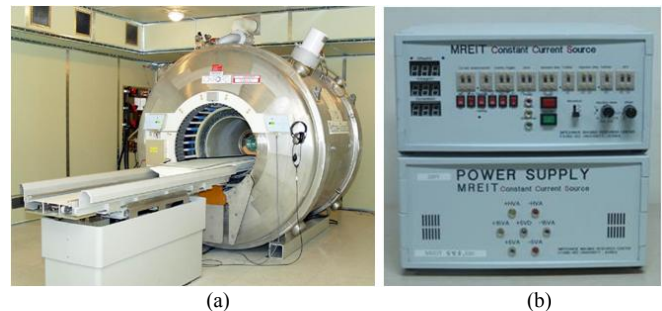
(a) 3 T MRI scanner and (b) MREIT current source at IIRC..
